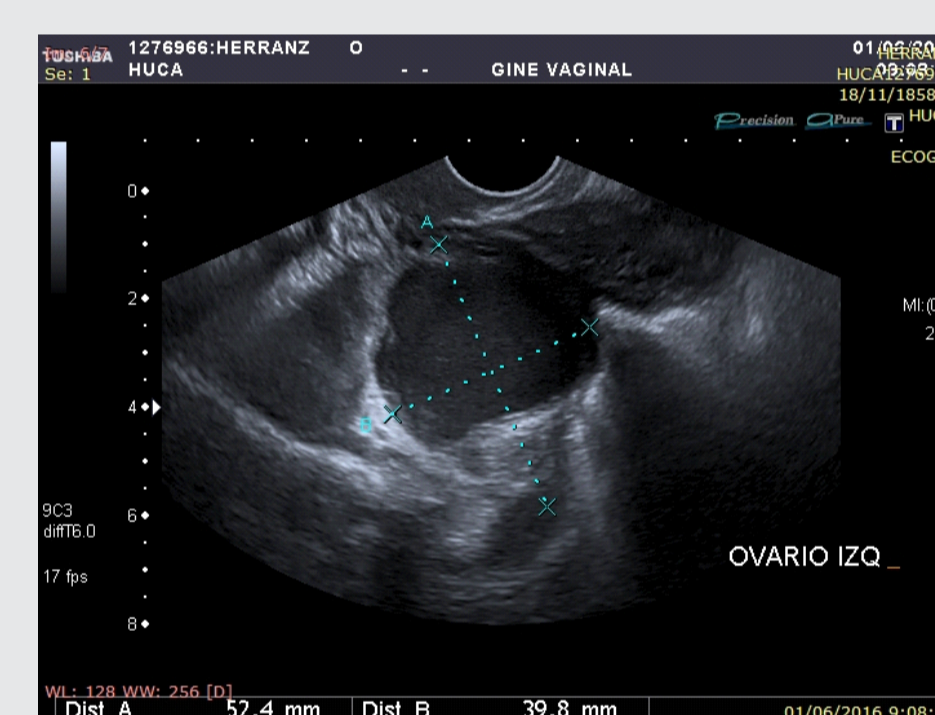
Basal ultrasound assessment. Diagnosis: endometrioma in left ovary
